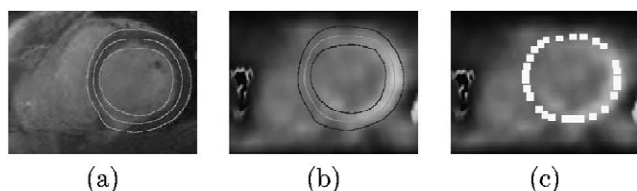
(a) Intersection of endocardial (inner contour), epicardial (outermost contour) and calculated medial (middle contour) surfaces with a MR SA slice, (b) the same contours are shown in the corresponding registered PET SA image (medial contour in the middle) and (c) the mean value of the FDG-uptake was computed at the medial surface nodes in a small neighborhood.
